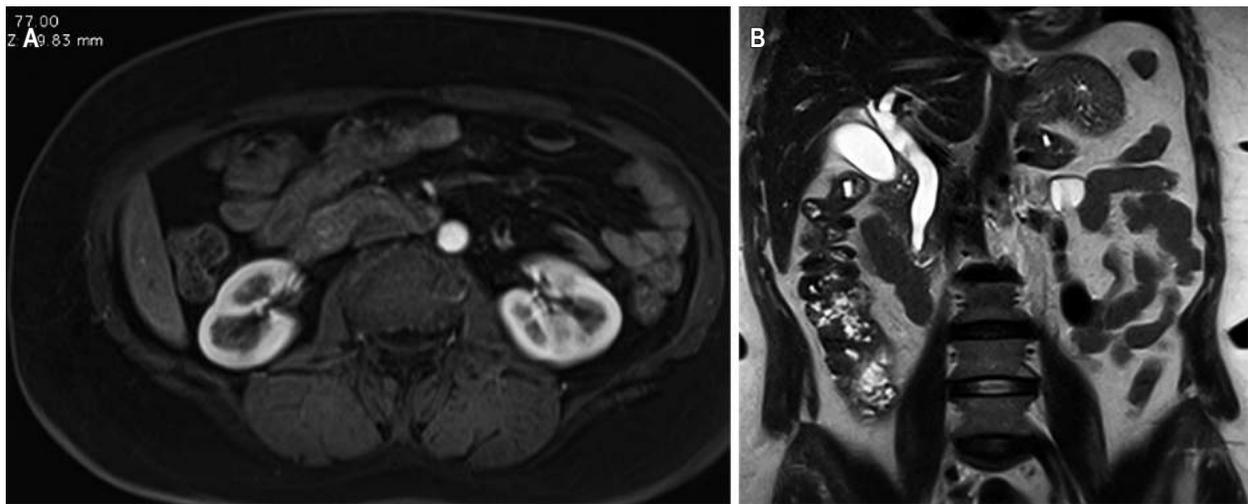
Magnetic resonance imaging contrasted with evidence of dilatation in the intra- and extrahepatic bile duct secondary to periampullary lesion (A) in the axial section and (B) coronal section. Source: Authors' archive.
